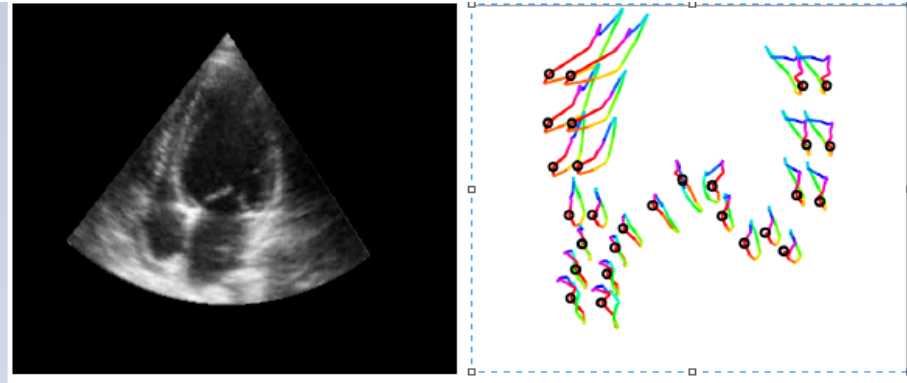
The picture of a normal person echocardiogram and the velocity movement profile of left ventricle
